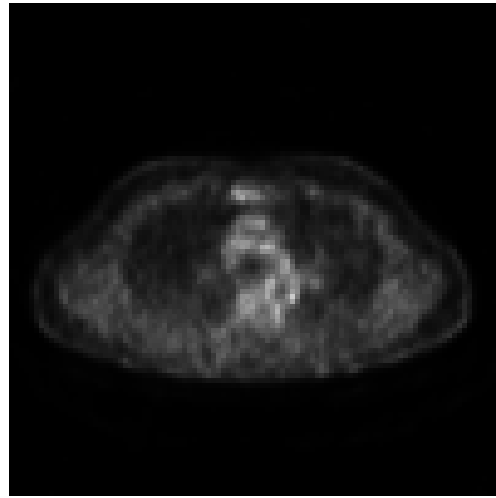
Nodule detected by PET image. Nodule was not detected using CT image because the nodule adhered to the thoracic wall. On the other hand, big nodule was detected using PET image since nodule has highly uptake.
